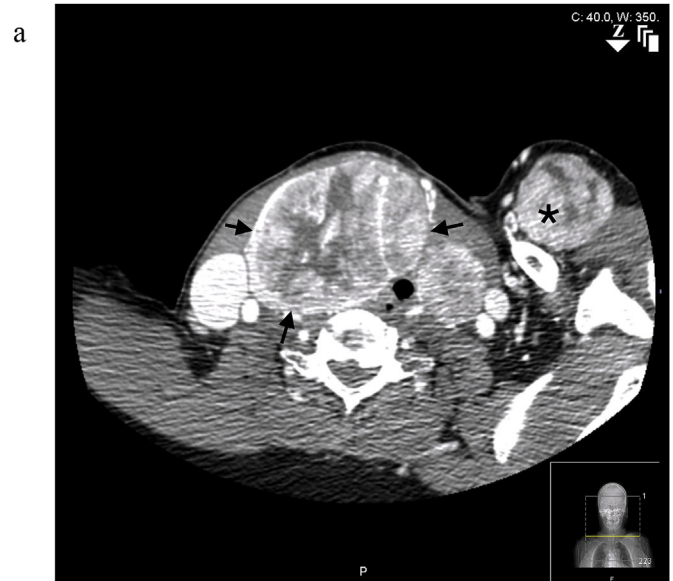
(a): Axial CT with contrast demonstrating enlarged, heterogeneously enhancing thyroid (arrows) and an ectopic mass anterior and inferior to the left clavicle (asterisk). (b): Coronal CT with contrast demonstrating enlarged, heterogeneously enhancing thyroid (arrows) and an ectopic mass anterior and inferior to the left clavicle (asterisk).
